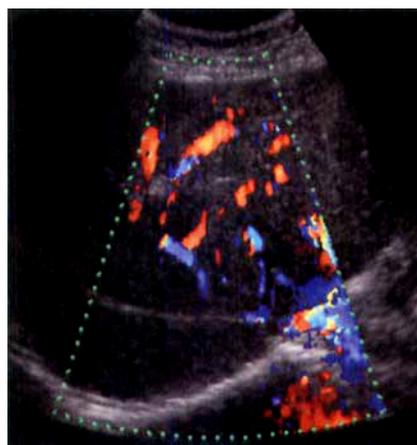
Color Doppler ultrasound image of the right liver lobe. Subcostal view showing (1) a scar formation located at the place of the completely obliterated right hepatic vein, (2) residual flow in the middle and left hepatic veins, and (3) atypical collateral flow
